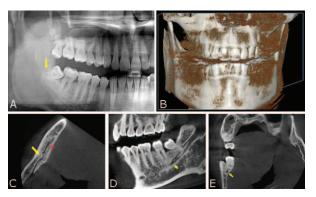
The panoramic (A) and CBCT (B–E) radiographic images of the patient. A, The panoramic radiograph of the patient. The arrow indicates the apex of the involved tooth (mesially tilted right third mandibular molar). B, The 3D reconstructive image of the cone beam computed tomography (CBCT). C–E, Sectional CBCT image of the involved teeth and bifid mandibular canal. In C (axial section), yellow arrow indicates the root apex of the involved tooth and red arrowhead indicates the bifurcation of the mandibular canal. In D (sagittal section), the arrow indicates section of the mandibular canal. In E (coronal section), the arrow indicates section of the partially separated shape of the mandibular canal.
